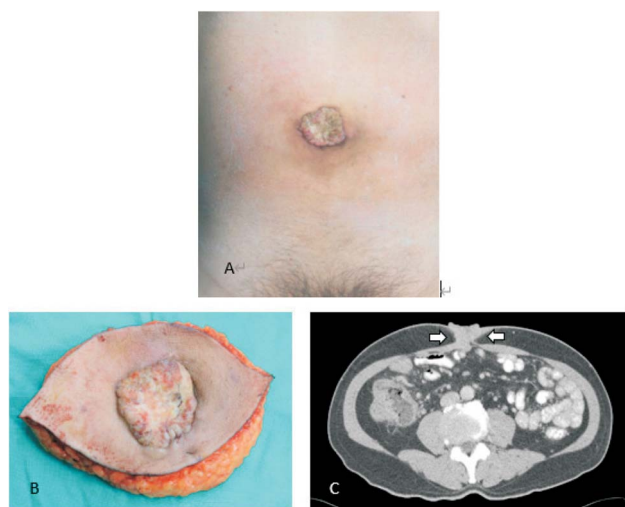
A 61-year-old man presenting with an enlarging umbilical mass was diagnosed with ascending colon adenocarcinoma with umbilical metastasis in 2015. He underwent right hemicolectomy. The pathology report showed pT3N2aM1a adenocarcinoma. Adjuvant chemotherapy with FOLFOX was performed after colon resection. Lung metastasis was noted after 11 months, and he underwent lung resection. He is now a long-term survivor, with over 63 months. (A) A 4-cm, hard, fungating tumor in the umbilicus. (B) Excision of the umbilical tumor with a 1-cm safe margin. (C) Computed tomography showed a full-thickness invasion of the abdominal wall of the umbilical tumor.
